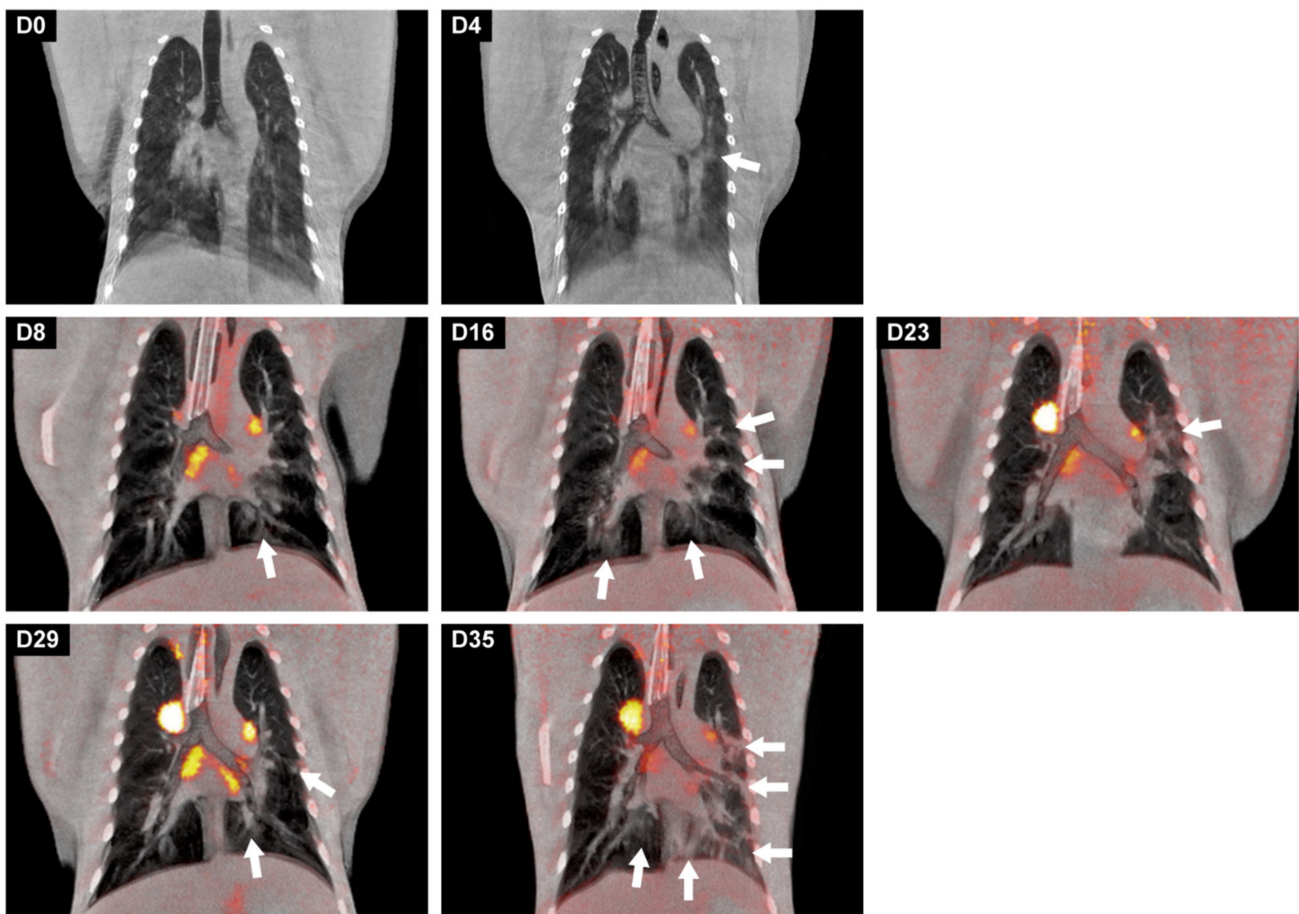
Longitudinal development of both lung lesions and metabolic activity in tracheobronchial lymph nodes of J16017 over time after a SARS-CoV-2 infection. Representative coronal slices with a thickness of 3 mm of J16017 were used for visualization. On days 0 and 4, only CT images were obtained, afterwards, until day 35, CT was combined with PET. The location of the lesions, marked with arrows, differed almost per time point, but are most prominently localized in the left lung on day 35.
